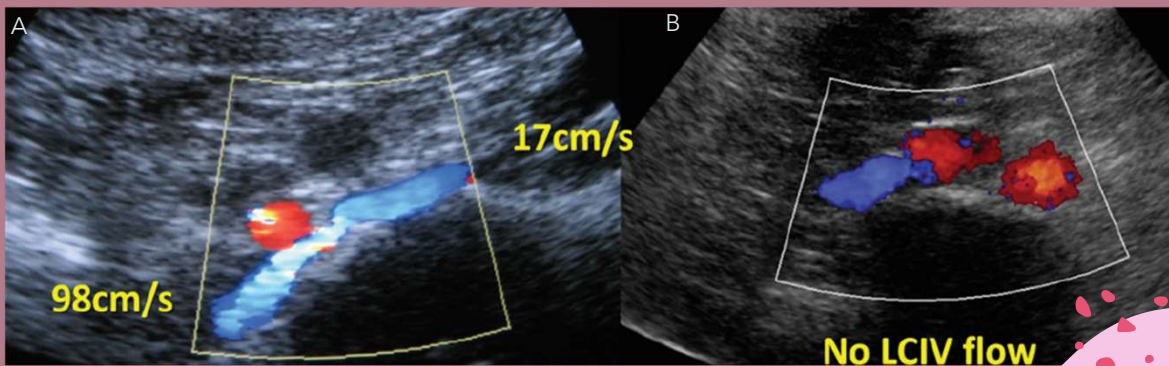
Transabdominal ultrasound imaging of the left common iliac vein demonstrating increased (A) and absent (B) flow on color Doppler imaging.<sup>13</sup>
